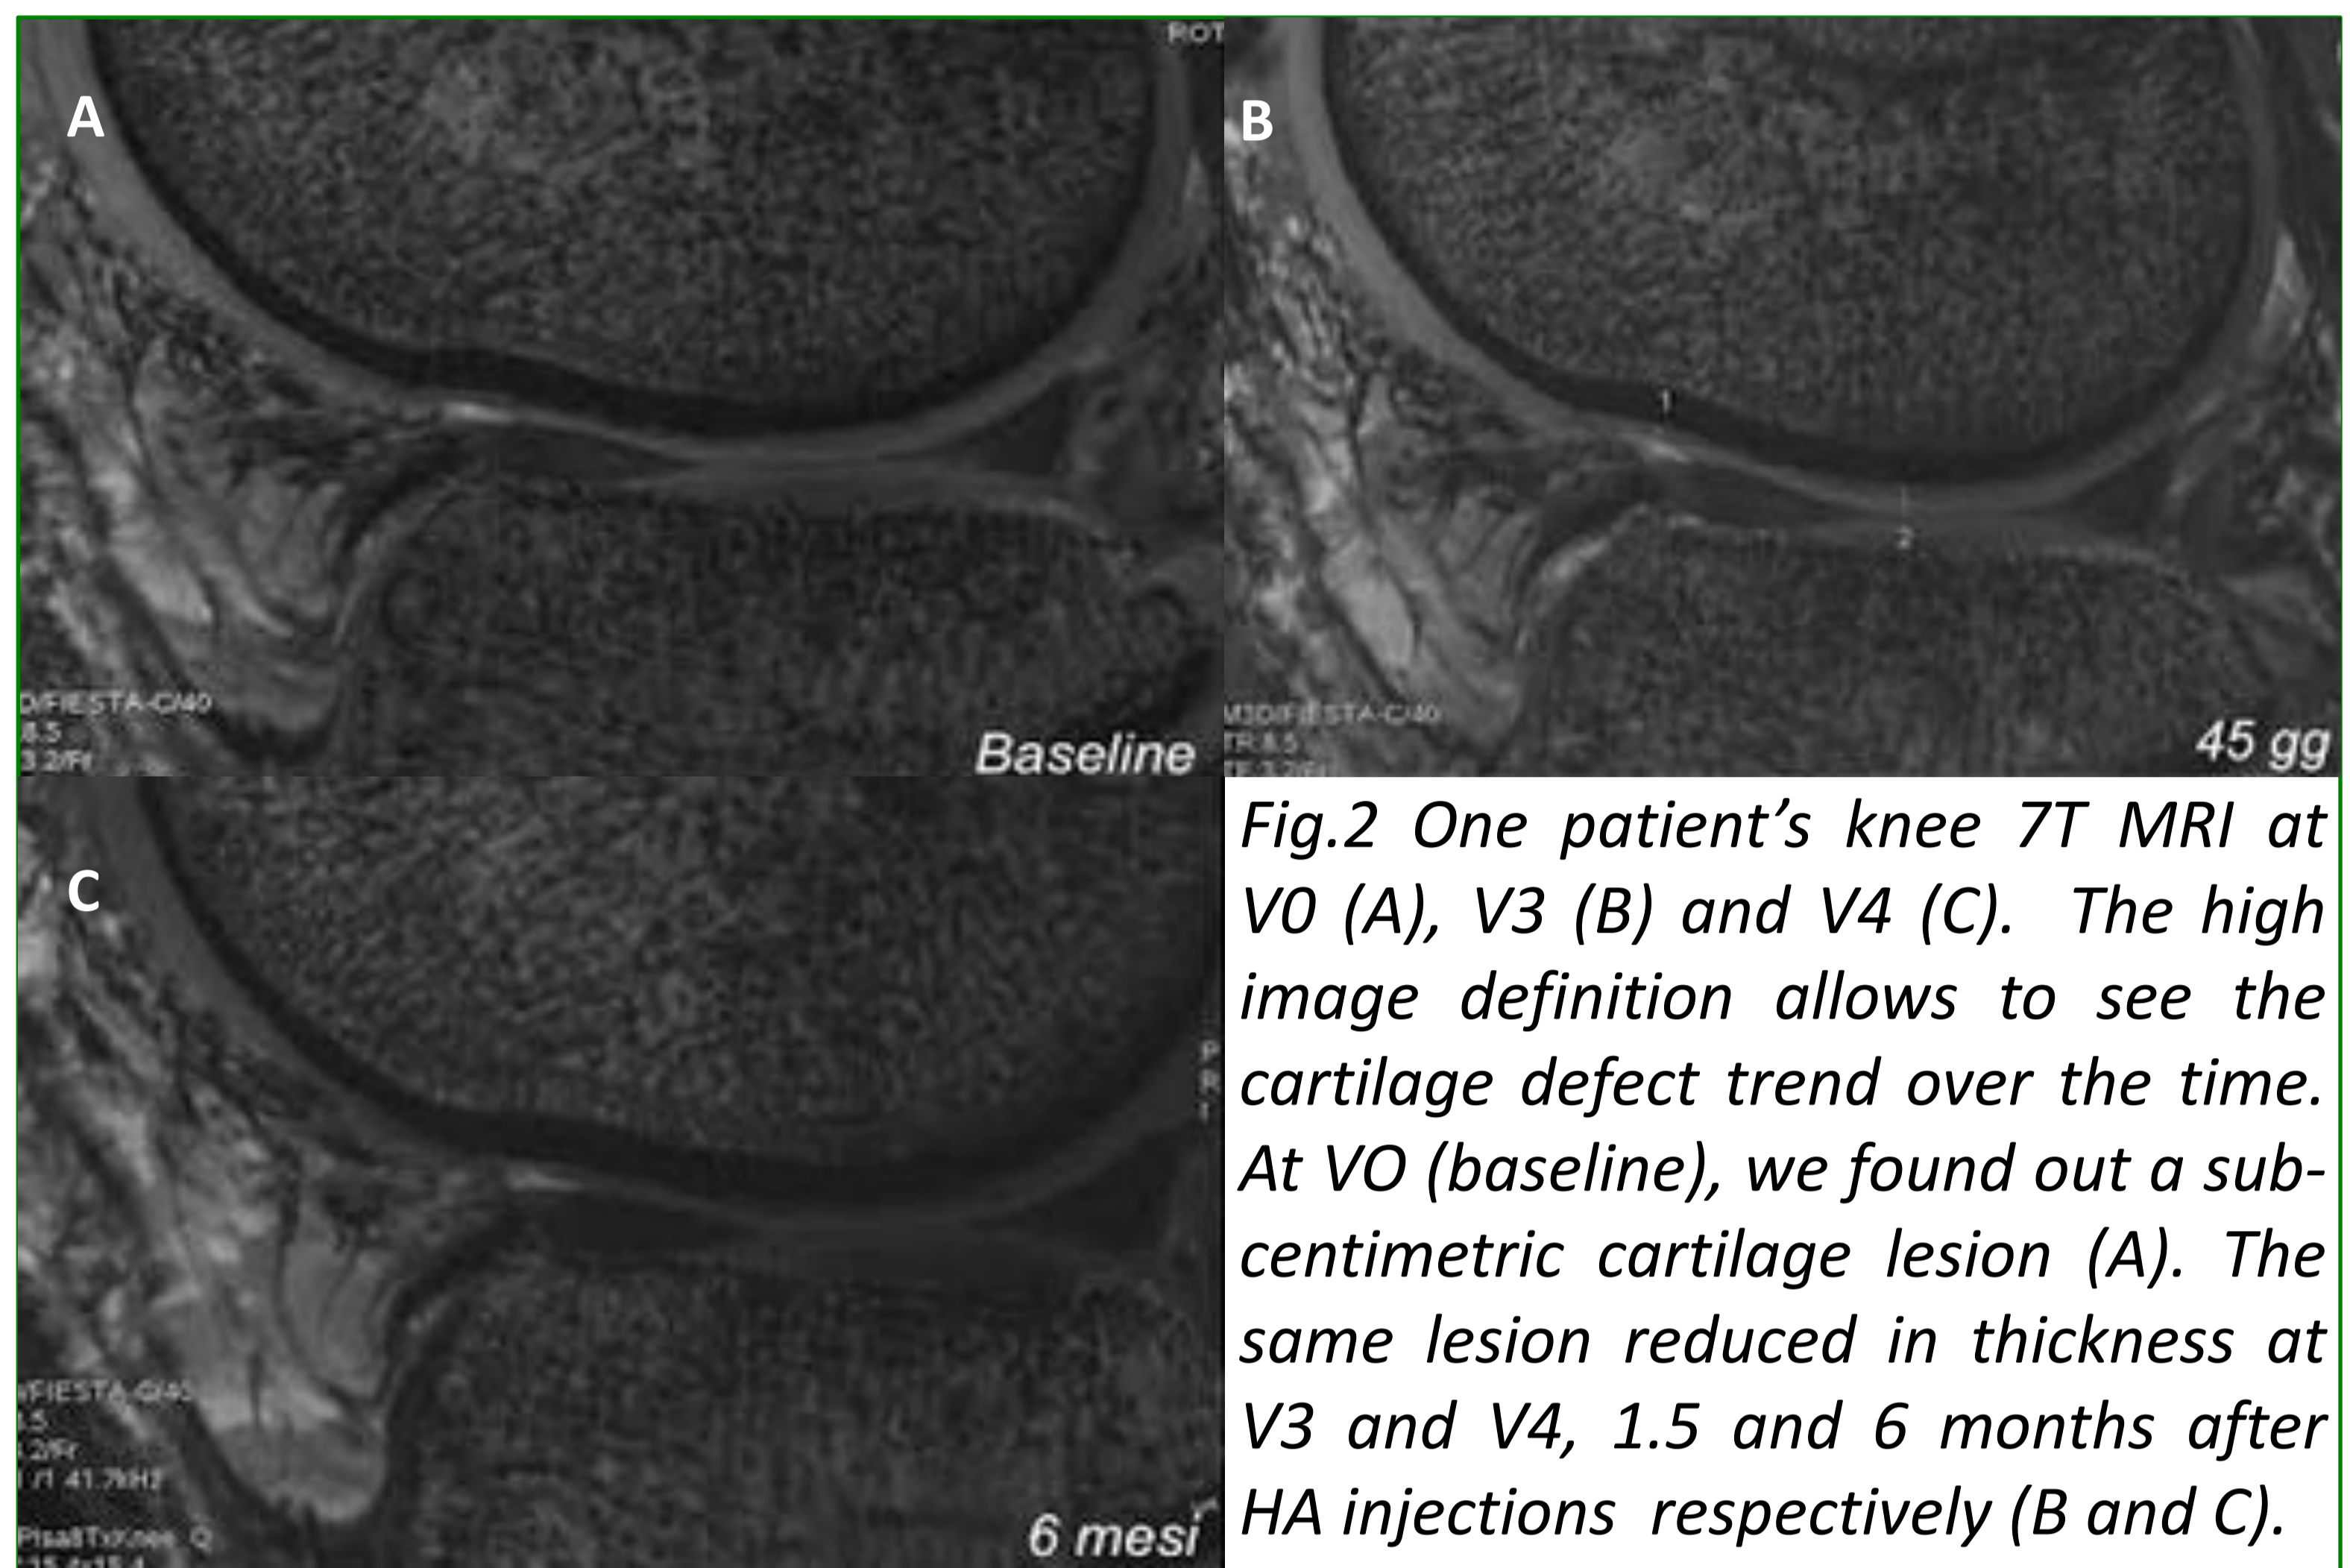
One patient's knee 7T MRI at V0 (A), V3 (B) and V4 (C). The high image definition allows to see the cartilage defect trend over the time. At V0 (baseline), we found out a sub-centimetric cartilage lesion (A). The same lesion reduced in thickness at V3 and V4, 1.5 and 6 months after HA injections respectively (B and C).
